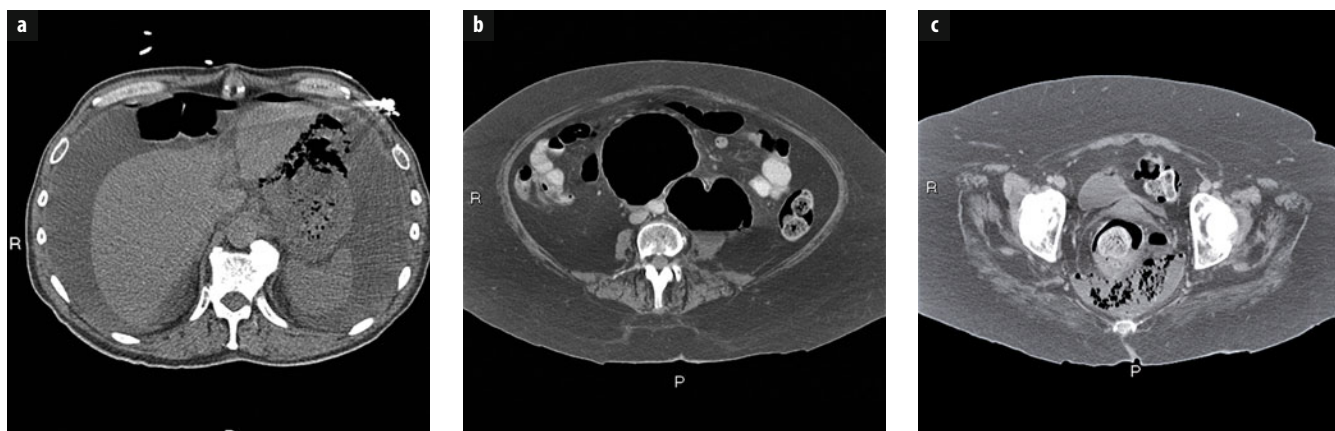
a-c. a A 63-year-old man with sepsis. Noncontrast axial computed tomography (CT) image shows a large amount of ascites, free intraperitoneal gas, and a large area of gastric perforation, with gas collecting immediately anterior to the stomach and lateral to the left hepatic lobe. At surgery, there was a gastric ulcer with associated regional gastric necrosis. b, c A 47-year-old woman with constipation, now with pelvic pain and an elevated white blood cell count. Axial CT image with contrast orally and IV (b) demonstrates two large adjacent abscesses abutting the aorta. Axial CT image through the pelvis (c) shows a posterior rectal perforation with a large, developing abscess and a “geode” representing solid stool in the rectum. The findings were due to a perforated stercoral ulcer
